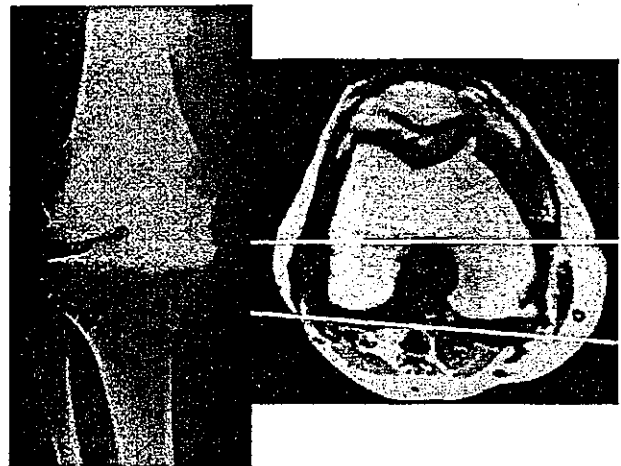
Standing AP radiograph of the varus knee (Left). Magnetic resonance image of the axial view of the distal femur in the varus knee (Right). The transepicondylar axis was externally rotated 6° from the posterior condylar tangent.
